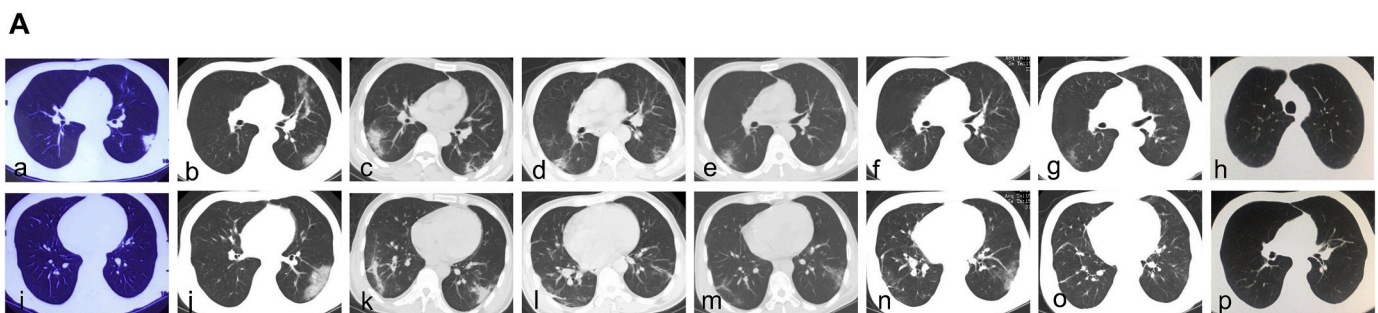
Changes in the patient depicted via chest computed tomography imaging. (a and i)symptom onset, single subpleural patchy ground-glass opacities(GGO); (b and j)On illness day 4, multiple subpleural patchy GGO; (c and k)On illness day 12,the worst CT image with multiple subpleural patchy GGO in bilateral lung; (d and l) and (e and m) on illness day 17 and 33, the lesion was gradually absorbed; (f and n) and (g and o) on illness day 38 and 58,the lesion was almost absorbed at a low speed; (h and p)CT image on pre transplant day, the lesion was absorbed without fibrotic shadow.
